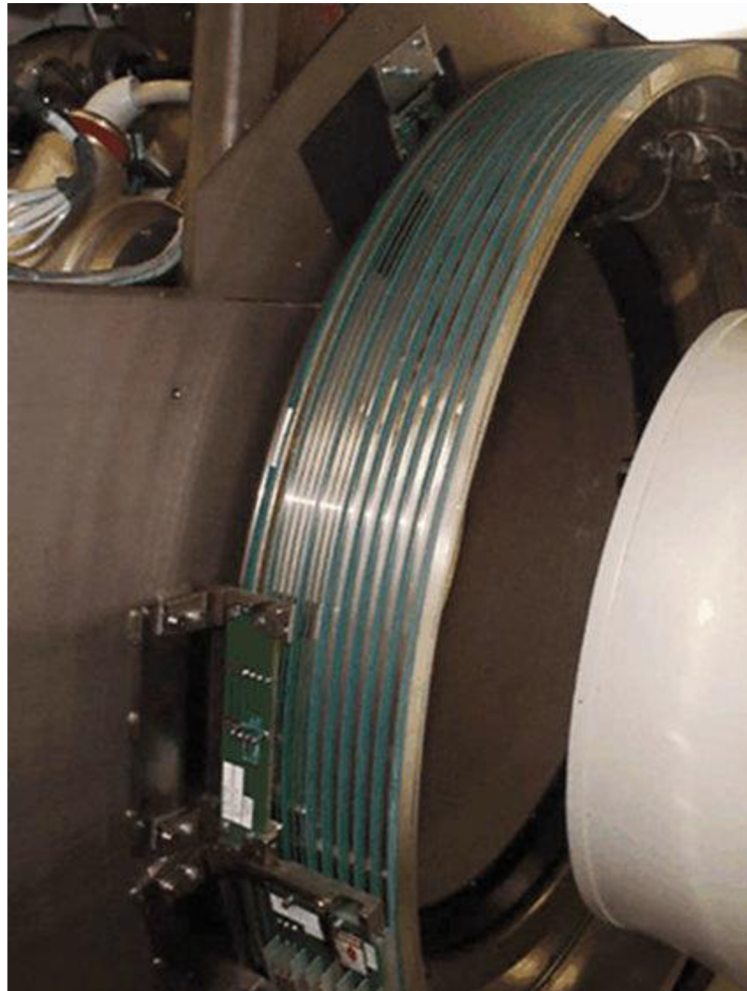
Slip ring in CT scanner. Retrieved May 17, 2016 from <http://www.wikiradiography.net/page/Slip+Rings>)
